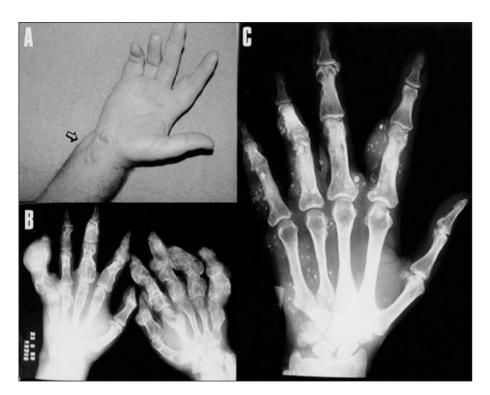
A (Patient 1), the skin of his wrist shows areas of bluish discoloration consistent with hemangiomas and phlebectasia. B (Patient 2), radiograph of the hands shows multiple radiolucent lesions with osseous expansible remodeling. C (Patient 1), radiograph of the hand shows well-defined round calcifications in the soft-tissue masses, typical of phleboliths.
